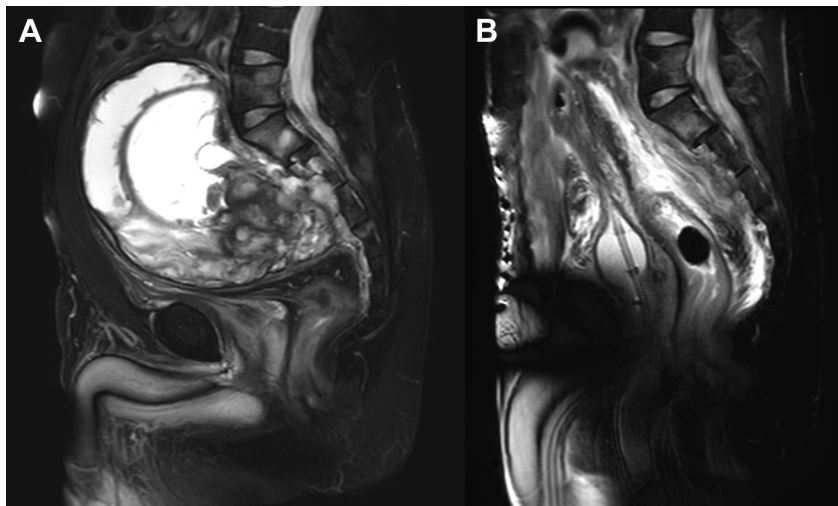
(A) Preoperative sagittal T2-weighted (T2WI) magnetic resonance imaging (MRI) showing a large retroperitoneal tumor involving the left hemipelvis and compressing the bladder and bowels. (B) Postoperative sagittal T2WI MRI showing complete removal of sacral schwannoma at 1 week after second surgery.
